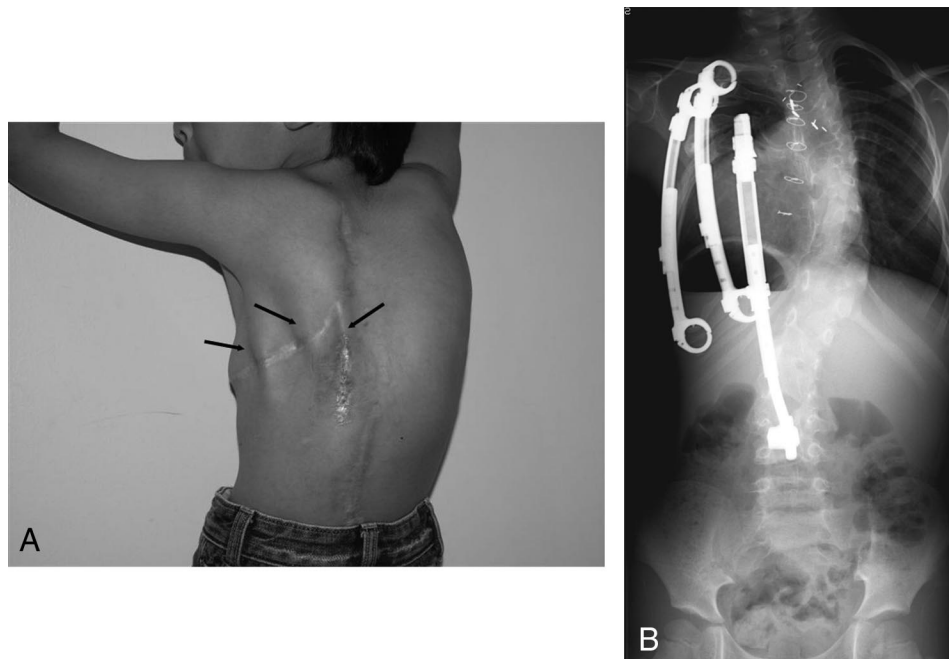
A, B: Thin body habitus of a typical VEPTR patient (A) with arrows pointing out the subcutaneous location of the VEPTR device seen in the accompanying radiograph (B).
